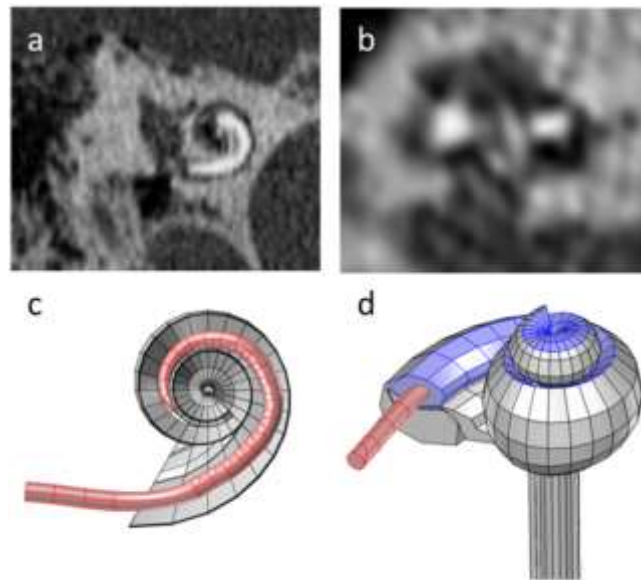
(a) Oblique view of the cochlea on a clinically obtained spiral CT image. (b) Mid-modiolar section through the same cochlea. (c) Visual rendering of the electrode inside the cochlea with structures removed to enhance visibility. (d) The complete model showing the electrode to be located in the scala vestibuli as a result of insertion through an incorrect cochleostomy site.
